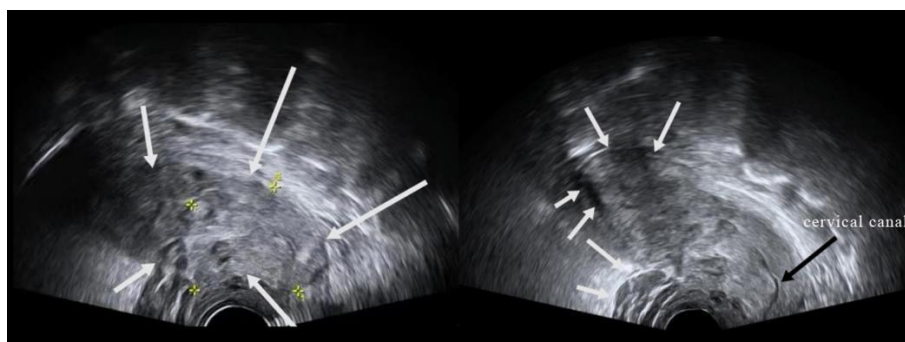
Transvaginal two-dimensional Doppler Ultrasound. There were continuously uneven echoes from the uterine cervix to the middle and lower uterine segments with the thickest part of 3.5cm and the cervical canals (pointed by black arrows)
